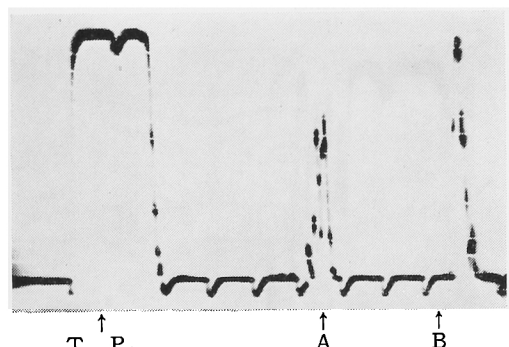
Ultrasono-echogram of Stone (B) Hanging in Water.
